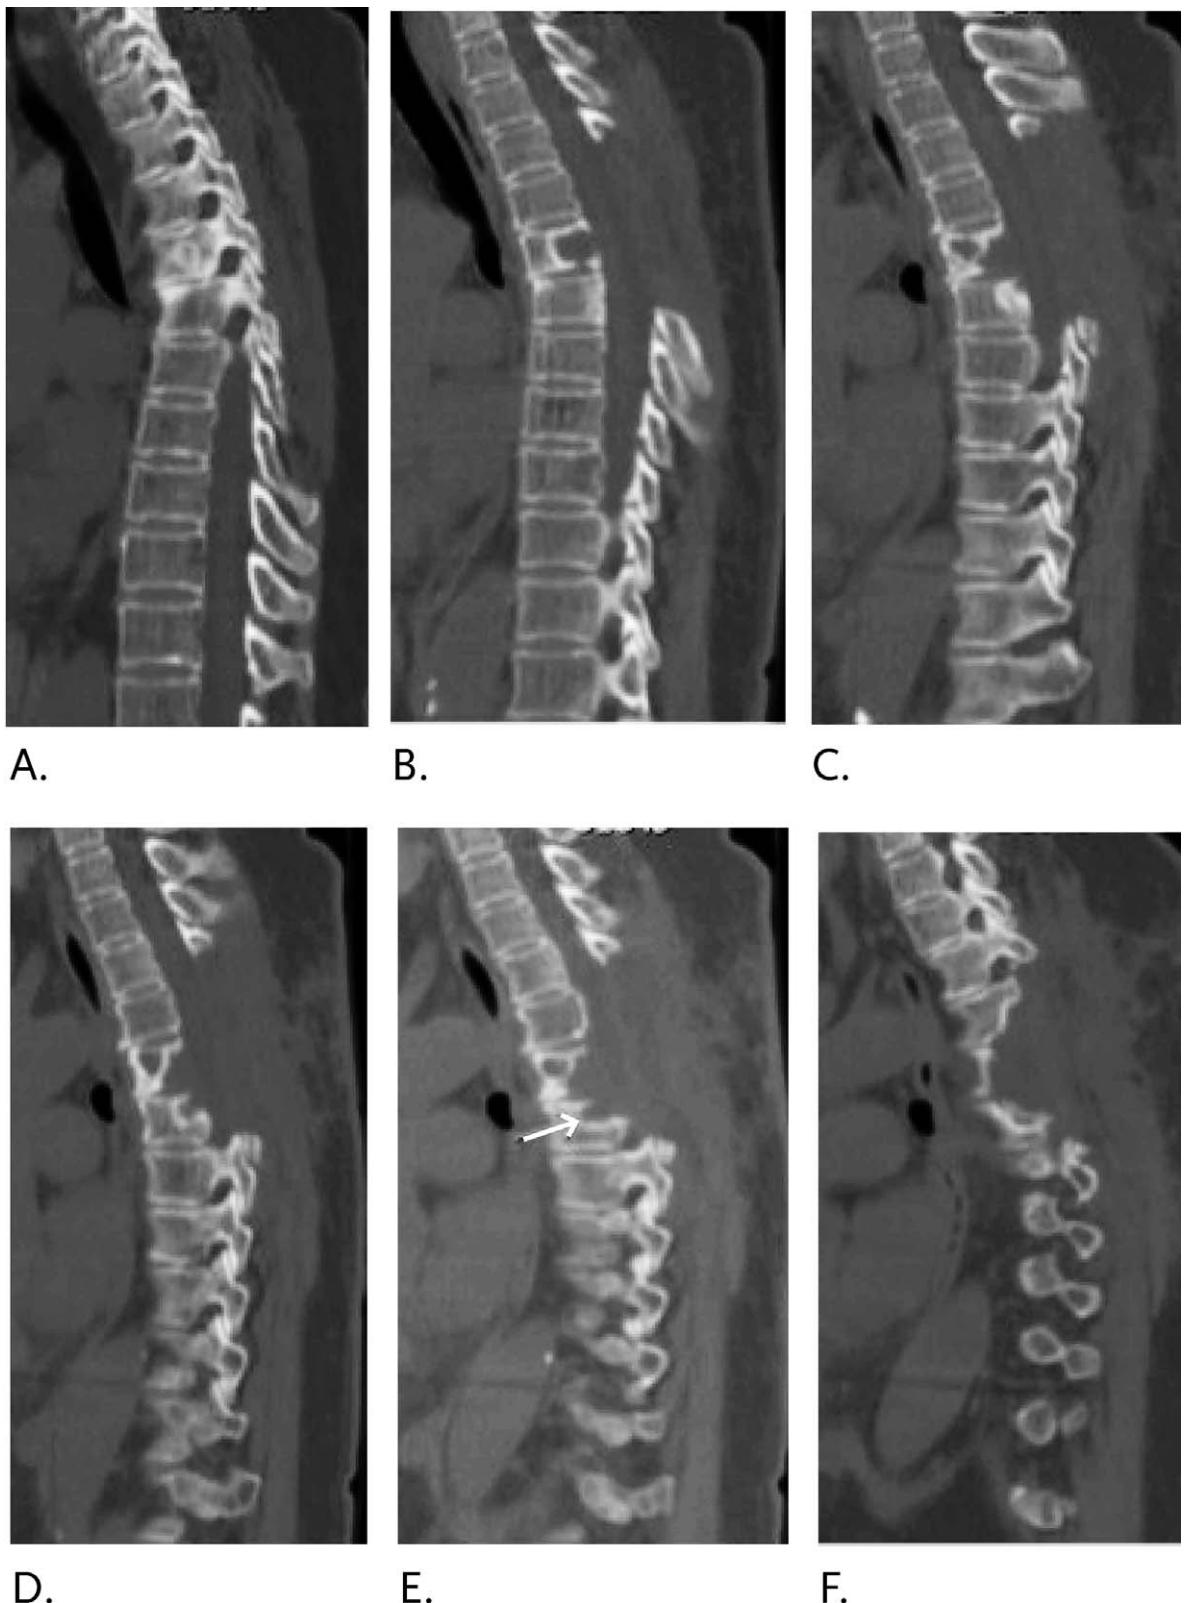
Sagittal computed tomography scan from right to left (A to F) showing complete tumor resection. The arrow in E indicates the sclerotic border of the vertebral body caused by the slow growth of the tumor.
